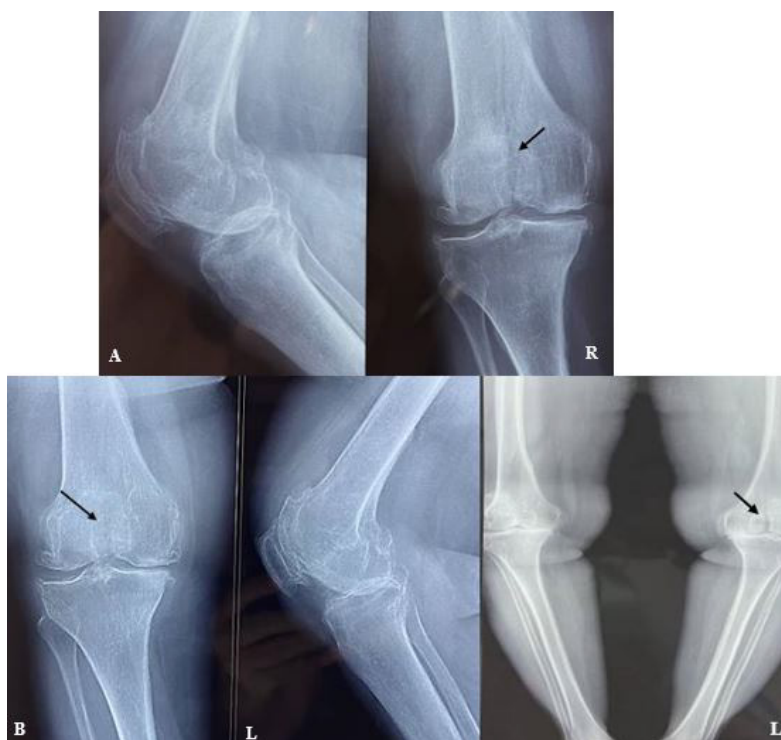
Anteroposterior and lateral plain radiographs revealed signs of osteoarthritis and A) a stress fracture of the right distal femur and B) left distal femur about a year and a half from the initial visit.
